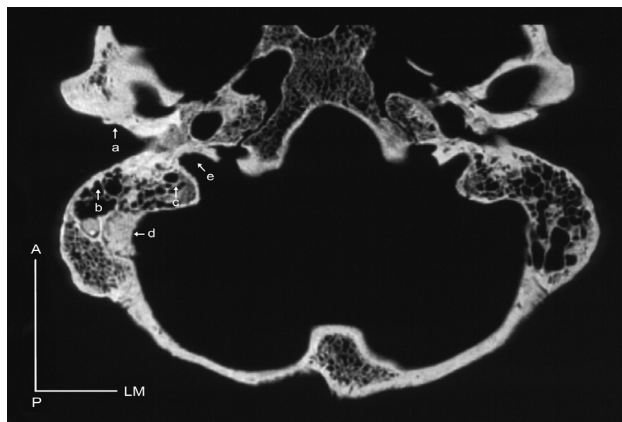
Axial CT scan at the level of both mastoid regions. Outer meatal exostosis (a), periapical mastoid cellules (b) intercellular mastoid septa (c), right sigmoid sinus groove fairly enlarged and filled with the sediment matrix (d), jugular foramen slightly enlarged (e).
